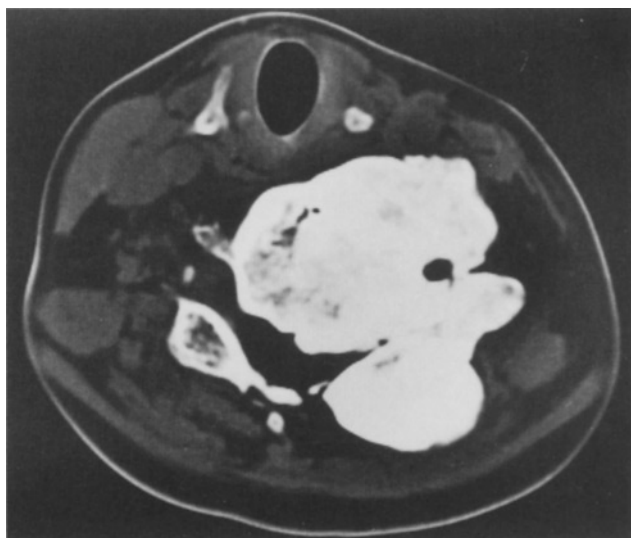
Axial CT image of the mass (December 1993). The mass is ossified.
